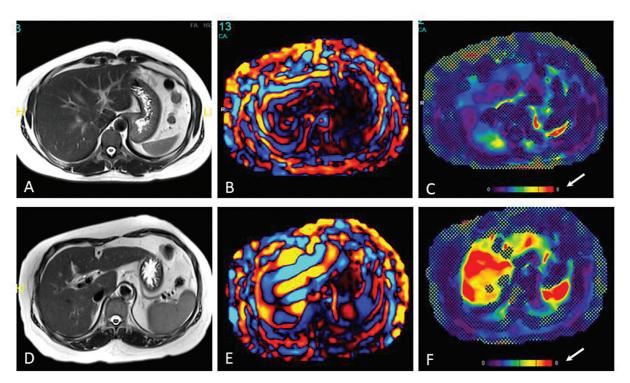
Principle of MR elastography. (A) T2W image of a normal liver. (B) Wave map generated in the normal liver shows smaller waves and, hence, slower wave progression. (C) Corresponding stiffness map shows predominantly blue–purple color suggestive of low LSM. Notice the color scale at the bottom of the image (arrow). (D) T2W image of another patient shows cirrhotic liver. (E) Corresponding wave map shows larger waves suggesting faster wave propagation. (F) Corresponding stiffness map shows predominantly red–yellow color suggestive of high LSM. LSM, liver stiffness measurement; MR, magnetic resonance; T2W, T2-weighted.
